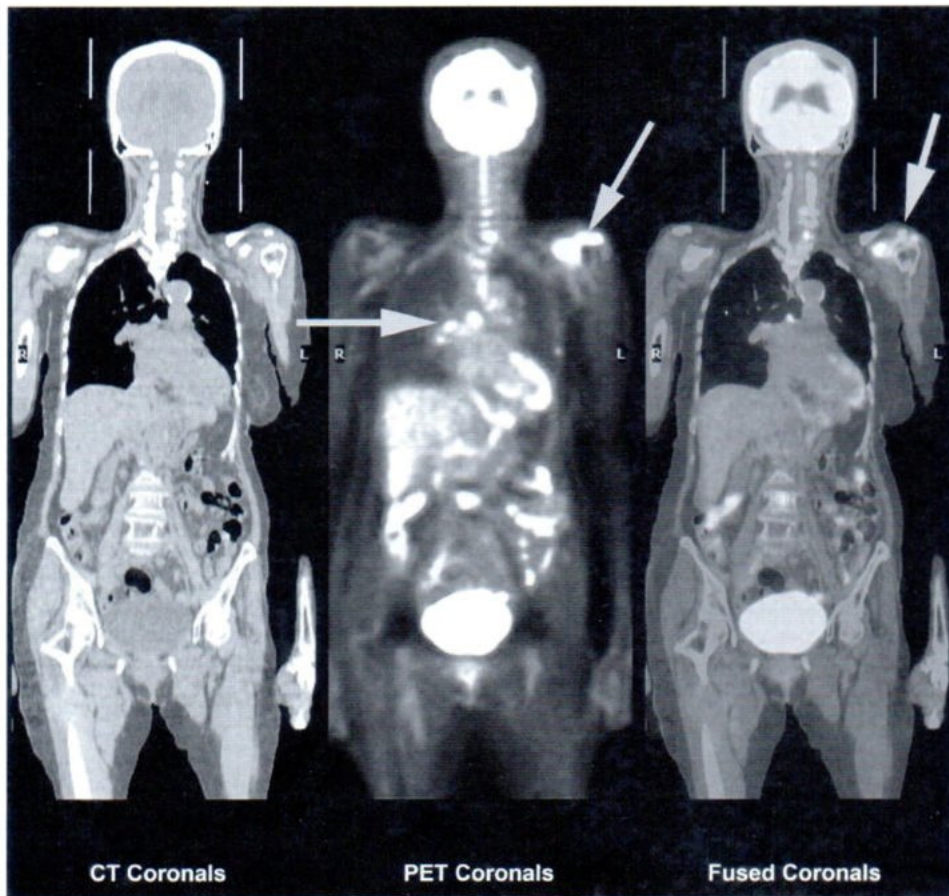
Coronal PET/CT scan shows multiple metastatic lesions at left scapula, right hilar and subcarinal nodes.
